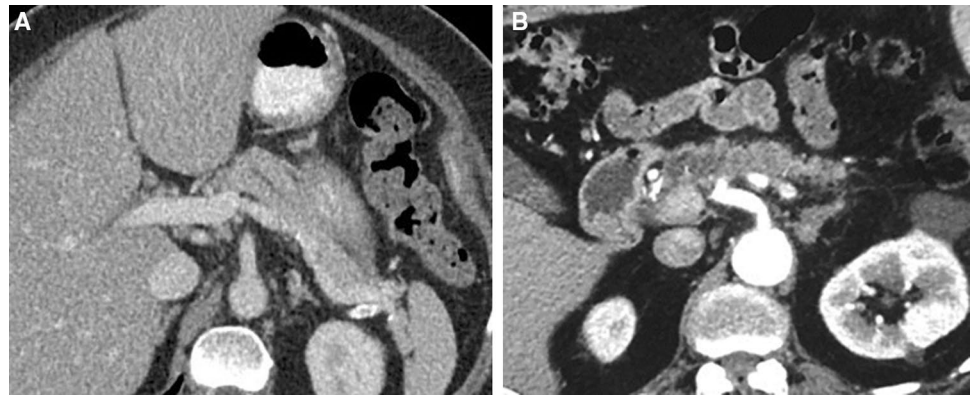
Pancreatic duct stricture: axial CT scan showing stricture (arrow) in body of pancreas
